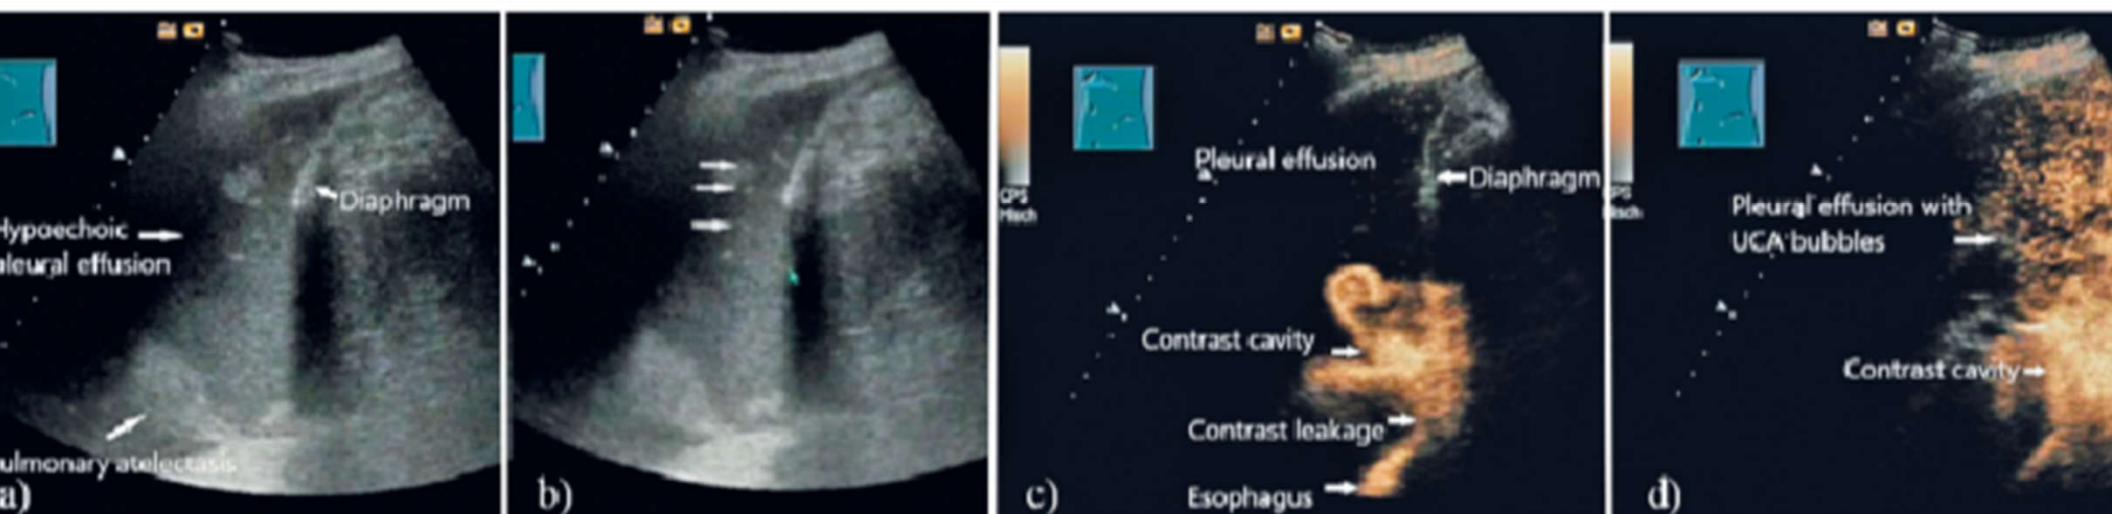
A patient in the intensive care unit with a history of severe reflux esophagitis, chest pain. Bedside ultrasound revealed a pleural effusion containing hypoechoic fluid (a). Ascending air bubbles were observed supradiaphragmatic (arrows) (b). Oral administration of the ultrasound contrast agent SonoVue as icCEUS. Exit of the UCA supradiaphragmatic, local accumulation paraesophageal supradiaphragmatic in a contrast "cavity" (c). The UCA bubbles disperse in the pleural effusion (d). The leakage of UCA from the esophagus into the pleural effusion was confirmed. Further diagnostic workup was performed with CT and gastroscopy. A fully covered esophageal stent was implanted. The pleural effusion was drained percutaneously.
